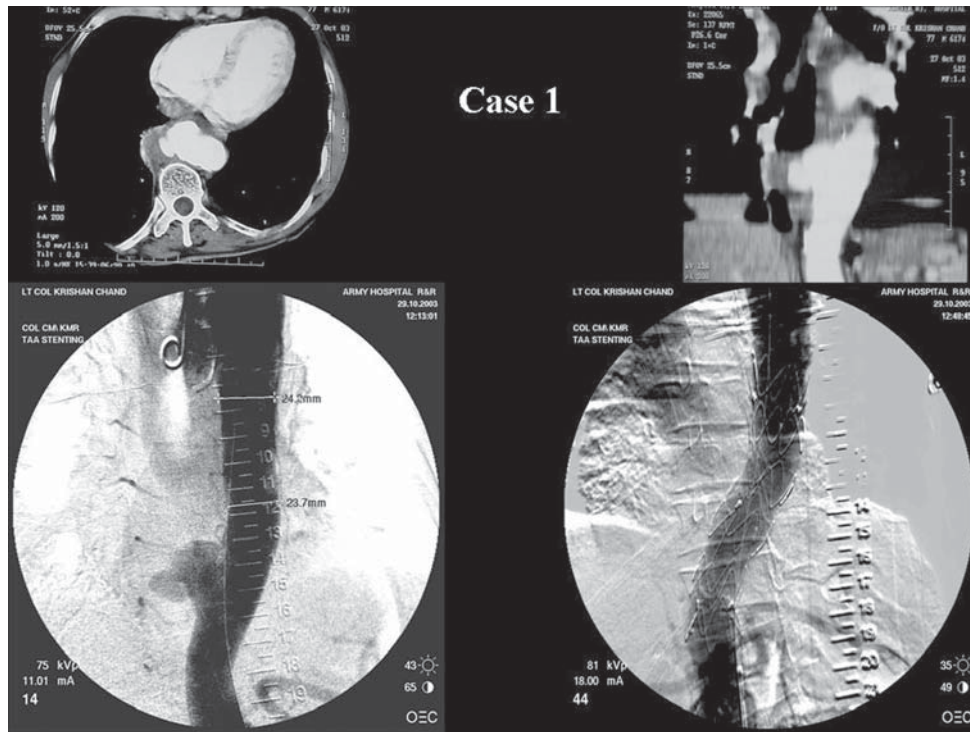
Case 1(Clockwise) I(a)&(b) Contrast enhanced CT scan shows a saccular aneurysm involving lower thoracic aorta. I(c) Digital Subtraction angiography outlines an irregular saccular aneurysm. I(d) DSA after successful exclusion of the aneurysm by inserted stent graft
